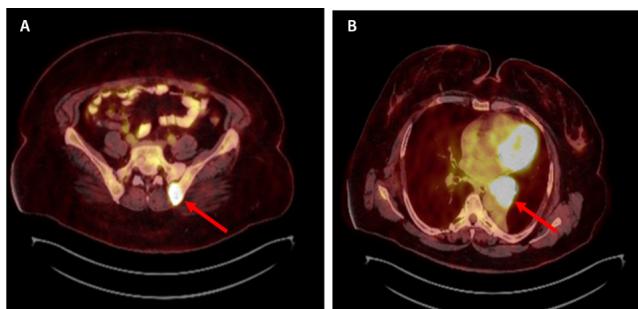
PET-CT at the time of diagnosis, A: Left iliac bone metastasis, B: Primary mass in the left lung.
